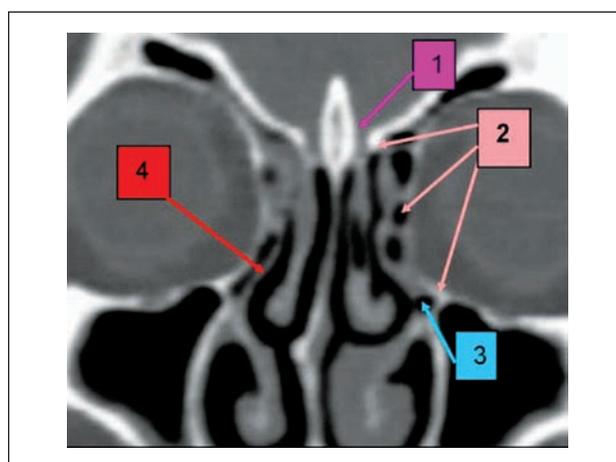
Paranasal sinuses CT scan, bone window, coronal slices: 1. skull base; 2. left uncinate process inserted on skull base, lamina papyracea, Haller cell, being adherent to the internal wall of the maxillary sinus; 3. left Haller cell; 4. right uncinate process inserted on lamina papyracea, narrowing the etmoidal infundibulum
